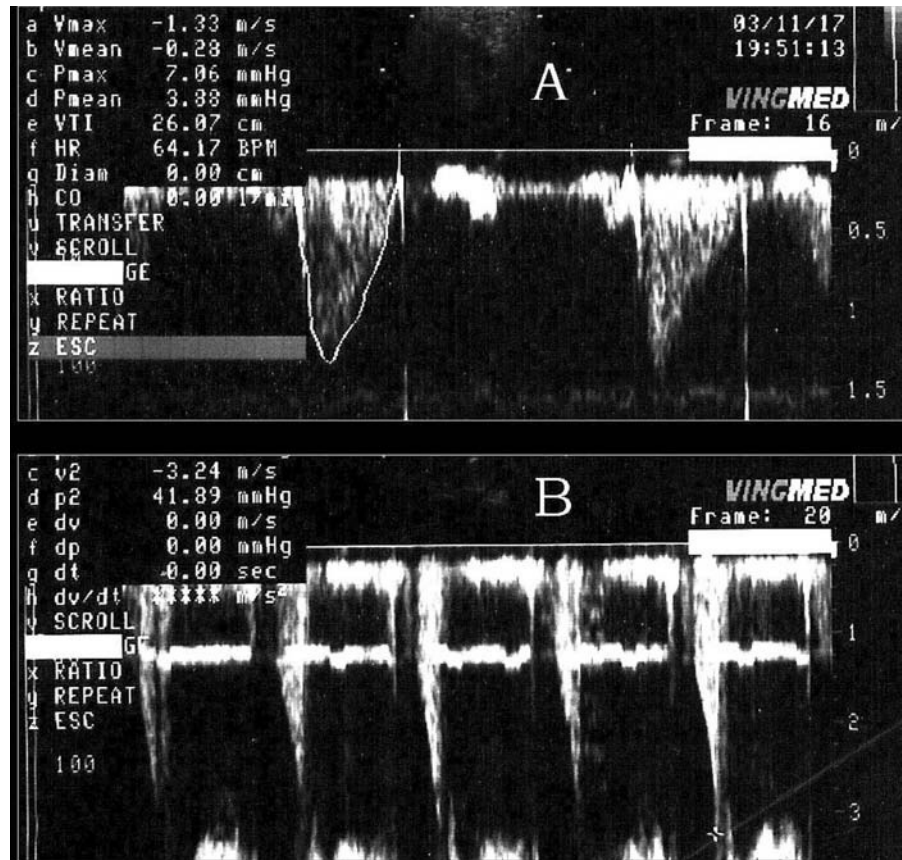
Continuous Doppler recordings of left ventricular outflow tract velocity, obtained at rest (A) and immediately post-exercise (B).
